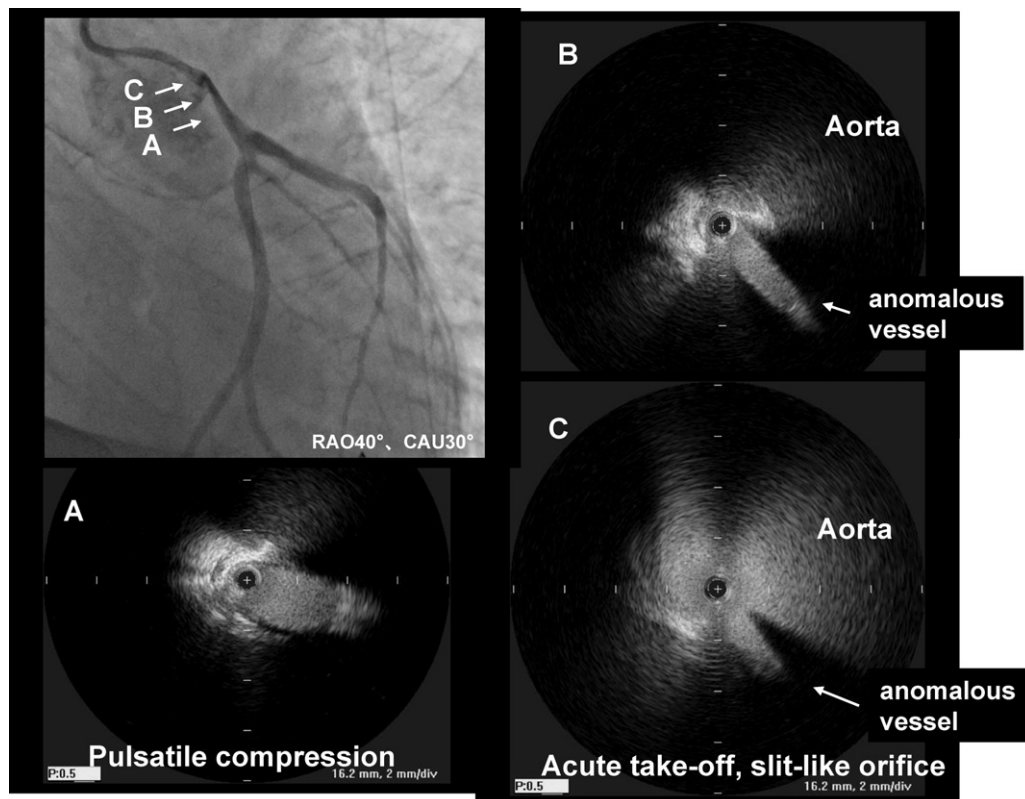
Intravascular ultrasound findings of the anomalous vessel. (A) Pulsating compression of the anomalous left main trunk with pressure from the outside. (B) Atherosclerotic changes. (C) Slit-like coronary orifice due to the acute takeoff of the anomalous left main trunk.
